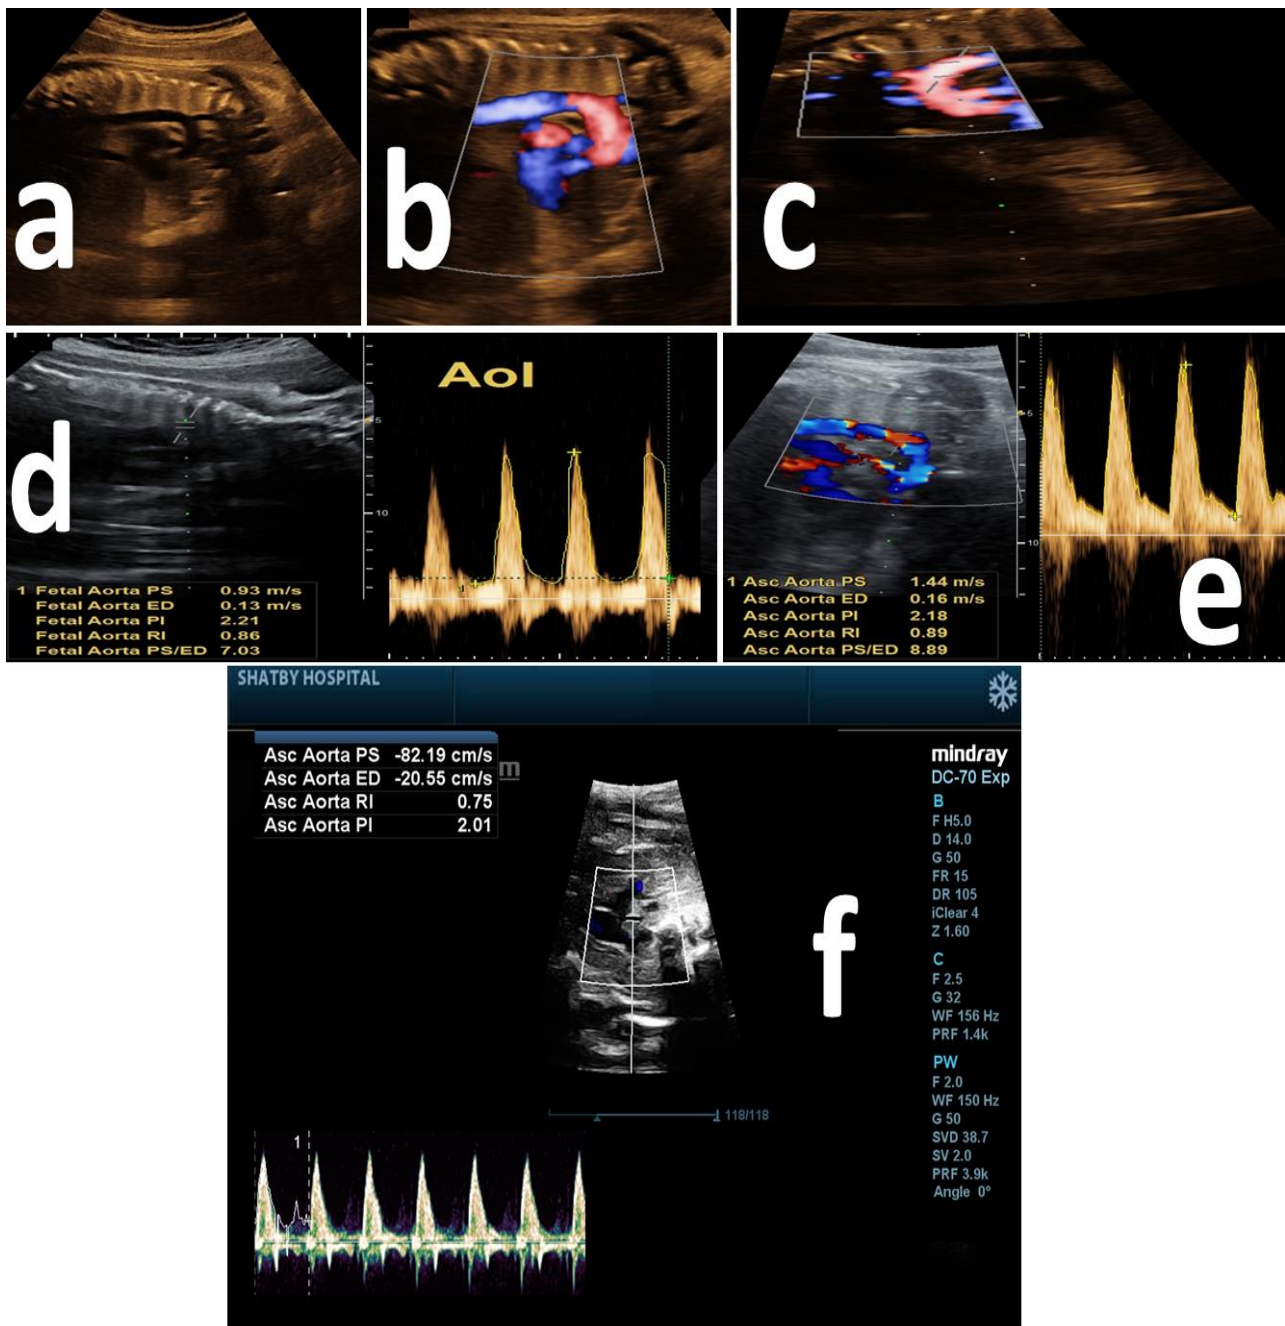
Doppler interrogation of the fetal aortic isthmus (a) aortic arch view in the sagittal plane using gray-scale ultrasound; (b and c) aortic arch view in the sagittal plane using high definition (HD) directional power Doppler; (d) pulsed Doppler velocimetry of the aortic isthmus in the sagittal plane using anatomical landmark (just caudal to the left subclavian artery) without using color nor power Doppler; and (e and f) pulsed Doppler velocimetry of the aortic isthmus in the sagittal plane after its identification using color Doppler.
